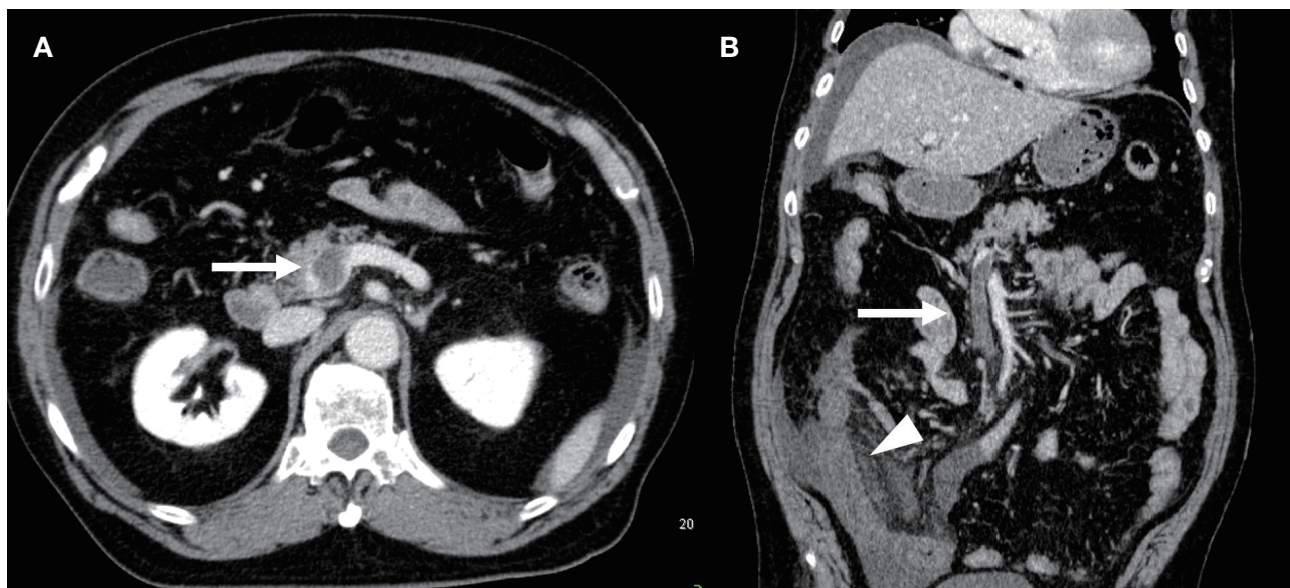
First dynamic CT. (A) Initial CT shows intraluminal thrombosis in the PV and the mesenteric vein (arrow). (B) Jejunal loop dilatation and diffuse wall thickening with ascites are evident (arrow head). CT, computed tomography; PV, portal vein.
